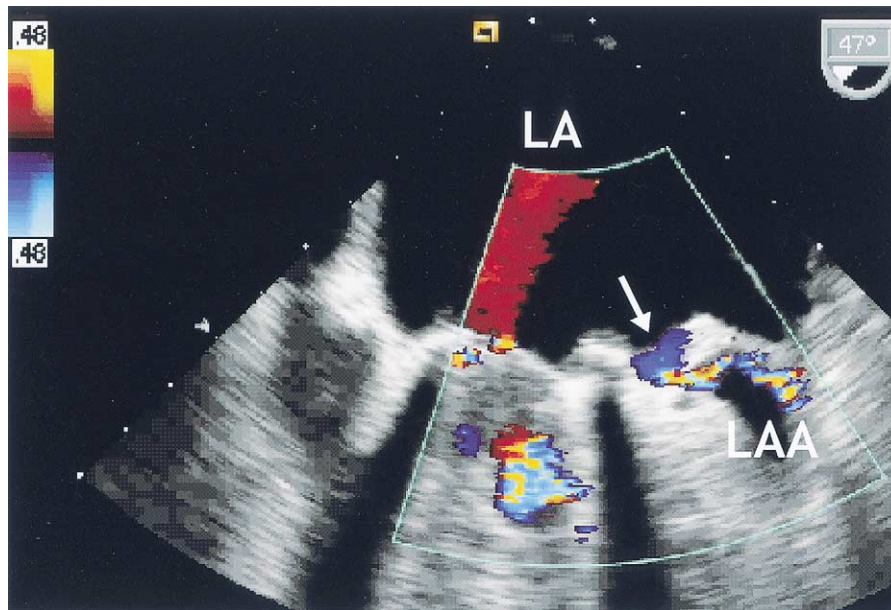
Transesophageal echocardiographic study. Transverse view of an incompletely ligated left atrial appendage (LAA). Color-coded flow transverses the communication between the LAA and the left atrium (LA) body (arrow).
